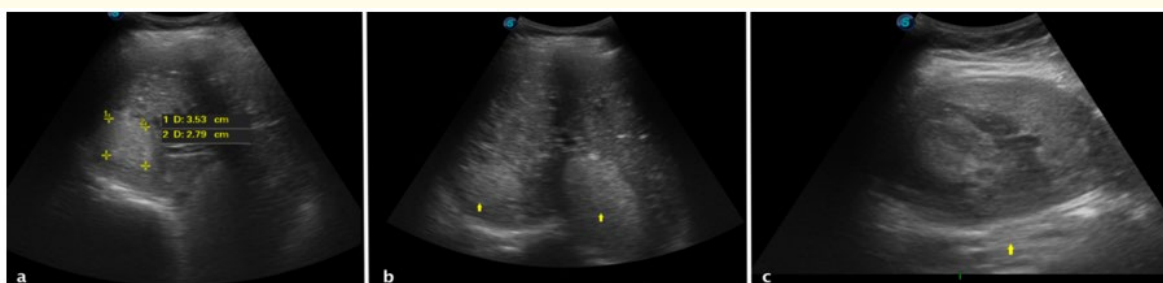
Abdominal ultrasound showing hepatic hemangiomas (a and b), and a heterogenous complex mass-like lesion in the left lobe (c).
